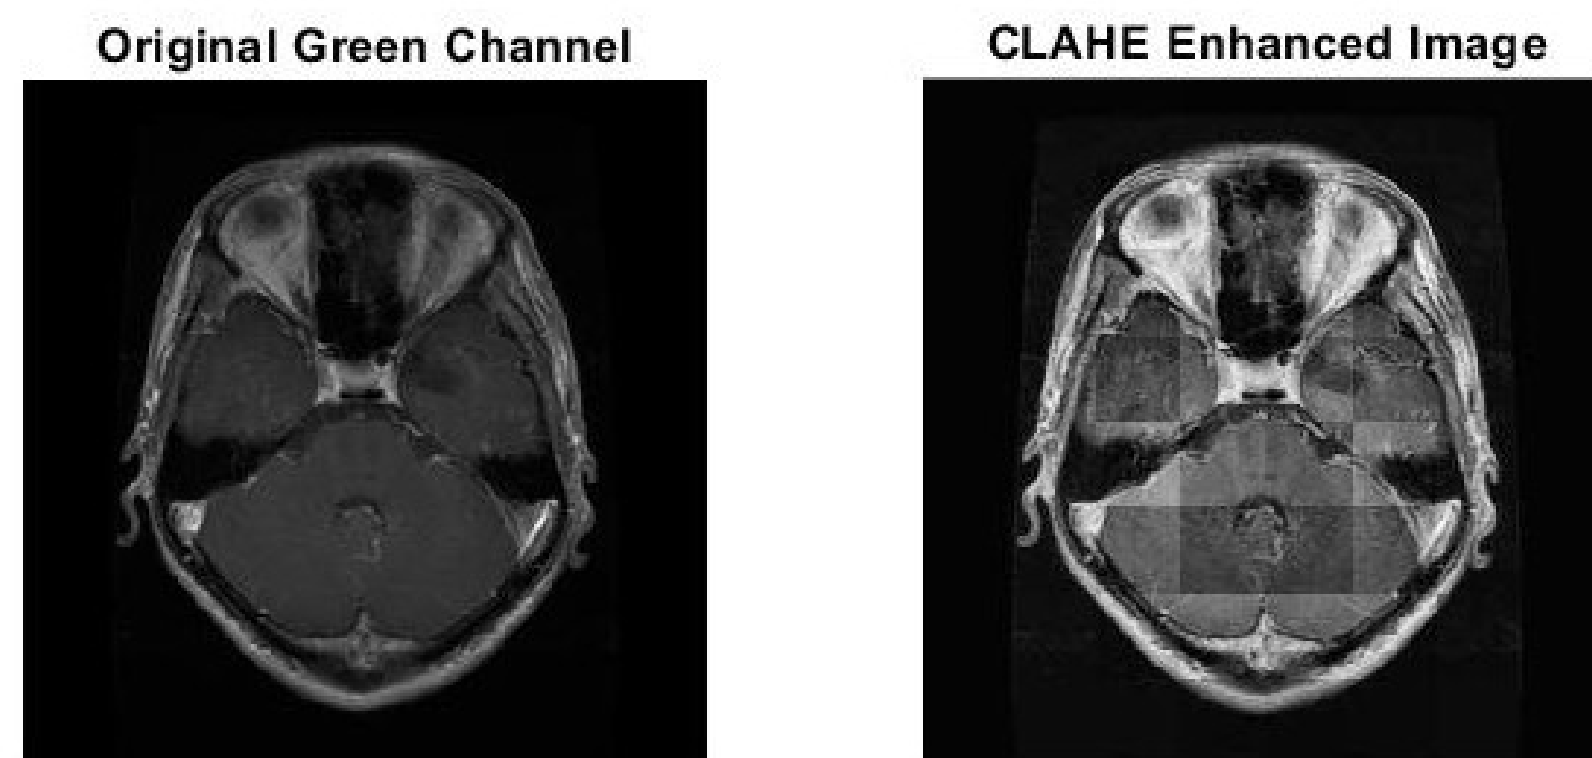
Brain MRI image before/after CLAHE
